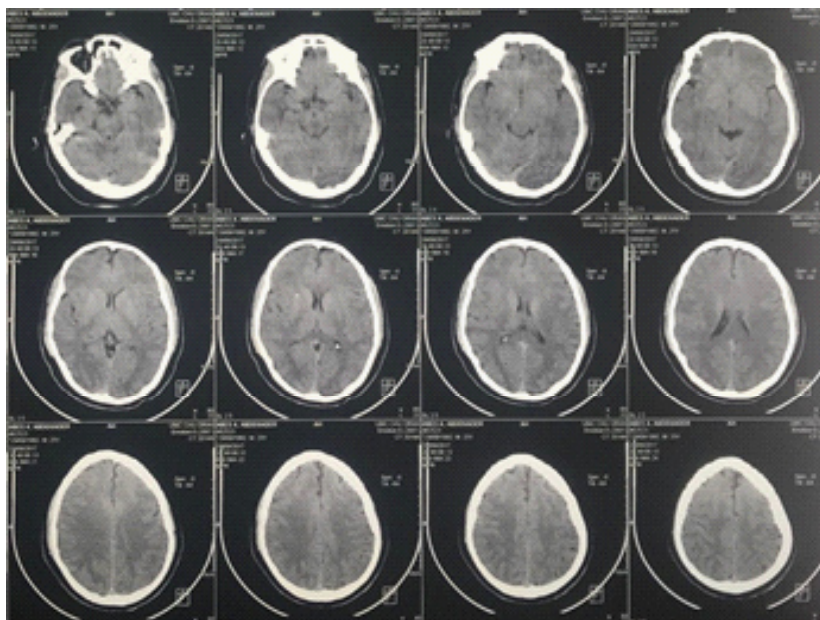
The brain CT scan evolution.
